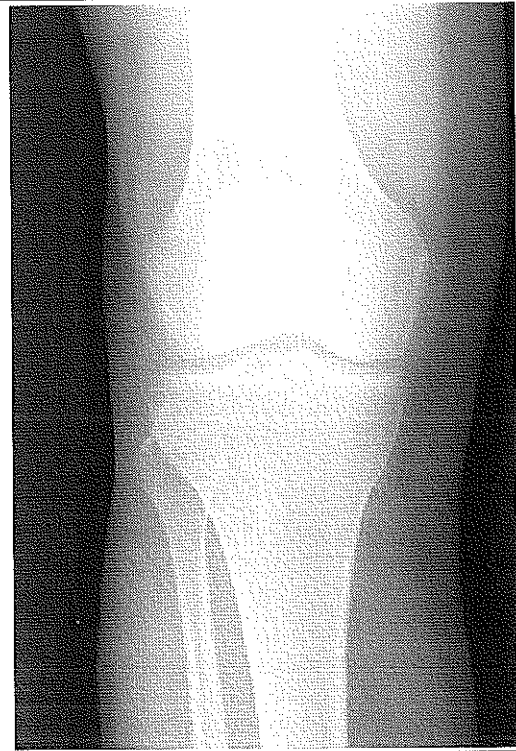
X-ray showing tibial plate fracture of right knee.
